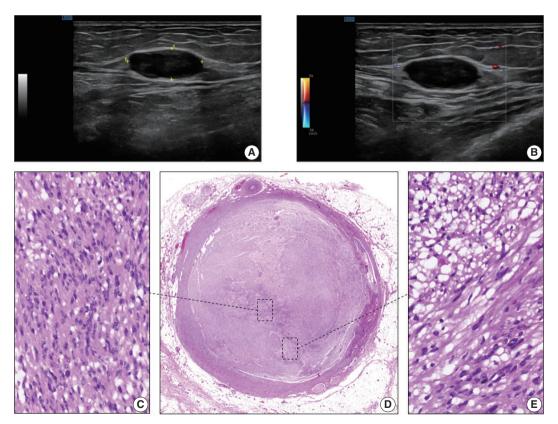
Ultrasonographic imaging and morphological features. (A) Ultrasonographic characteristics of the tumor showing a 2.3 cm hypoechoic ovoid nodule. (B) Low blood flow around the tumor in the Doppler ultrasound view. (C) Hypercellular areas that consist of cohesive spindle cells (Antoni A zones). (D) The tumor shows an intravascular growth pattern, occupying the entire lumen of the blood vessel. (E) Hypocellular areas that consist of haphazardly arranged spindle cells in a loose myxoid stroma (Antoni B zones).
